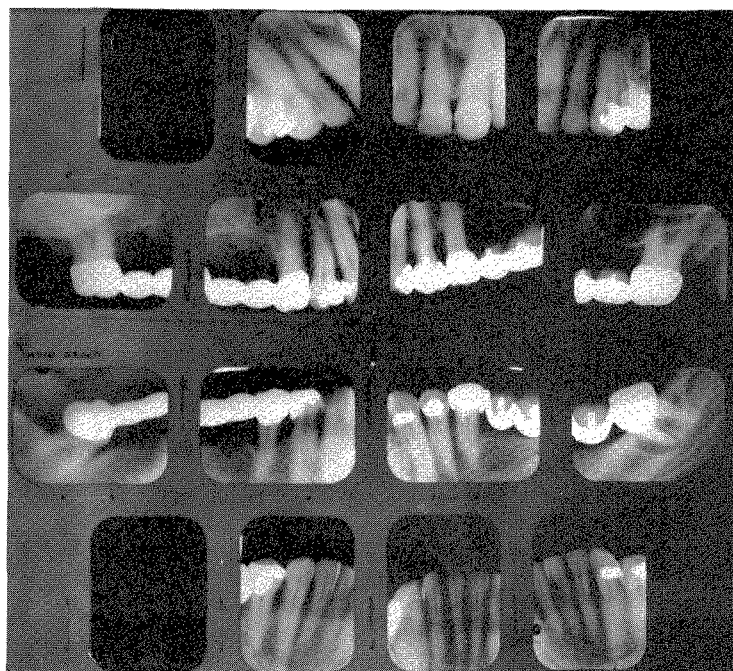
Roentgenograms taken in 1945. The patient was 51 years old. The lower left and the upper right molars were deeply involved in periodontal disease as were several other teeth.
